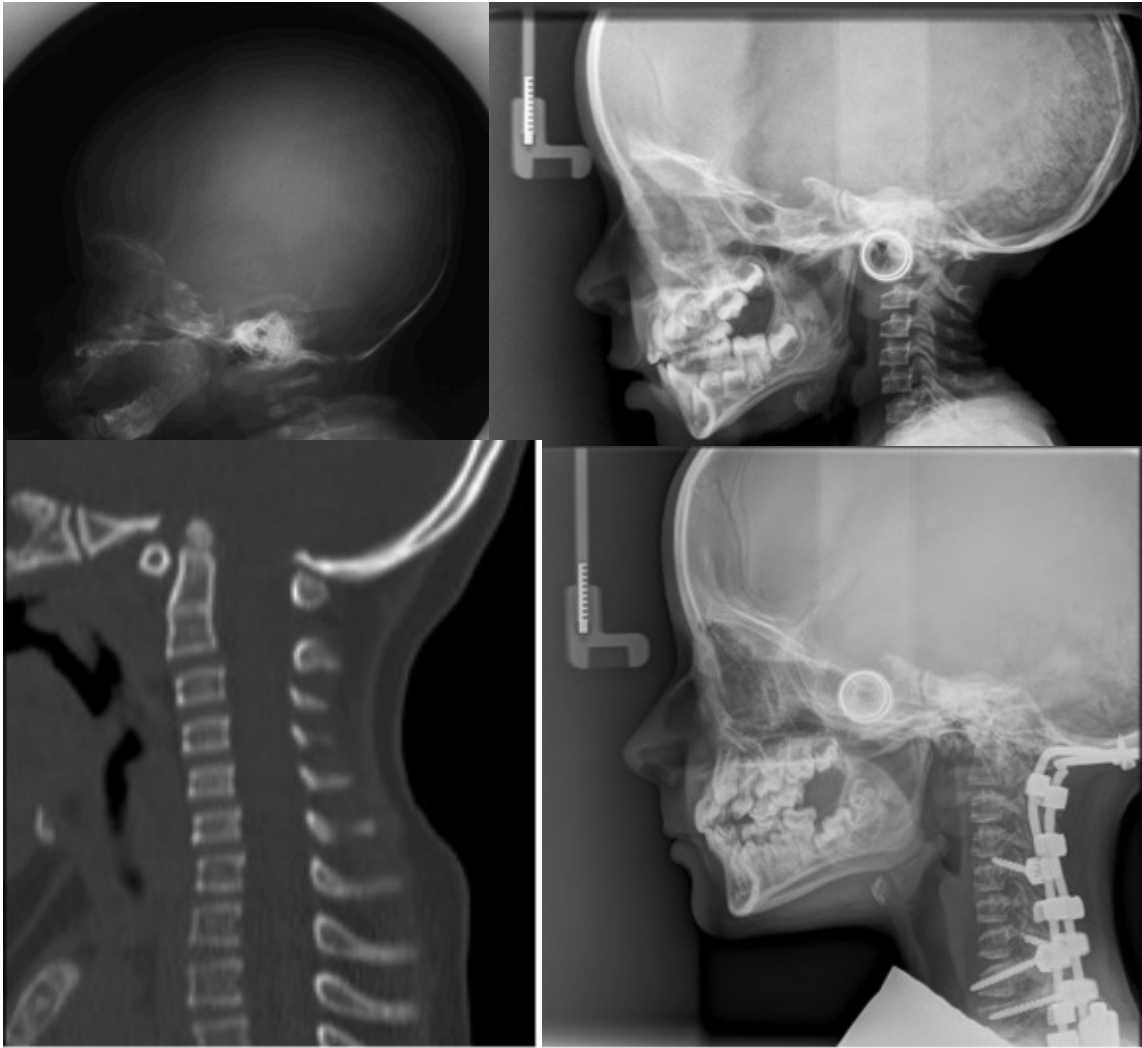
Radiographs of a male with OI type III A) at birth and B-D) at ages 7.5, 8.5, and at 11.7 years. The patient presented with platybasia from birth and developed basilar invagination and impression by 4 years of age. Surgical decompression and posterior fixation was conducted at the age of 8 years due to evolution of Chiari I malformation following the craniocervical anomalies. The patient had been treated with bisphosphonates from the age of 4.5 years. Image D obtained after the surgery was not used in the longitudinal analysis.
